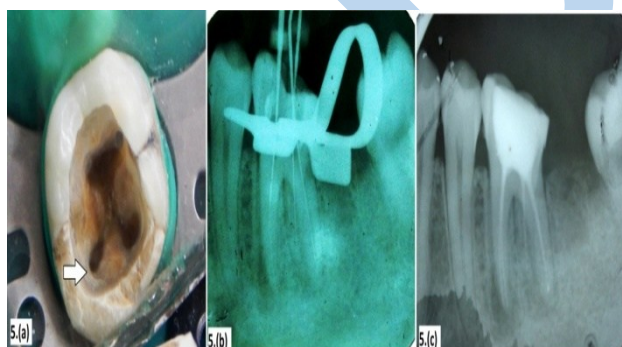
(a) Clinical picture of pulp chamber floor showing orifice of distolingual canal of tooth#46, 4.(b) Working length radiograph of tooth#46, 4.(c) Radiograph after obturation
